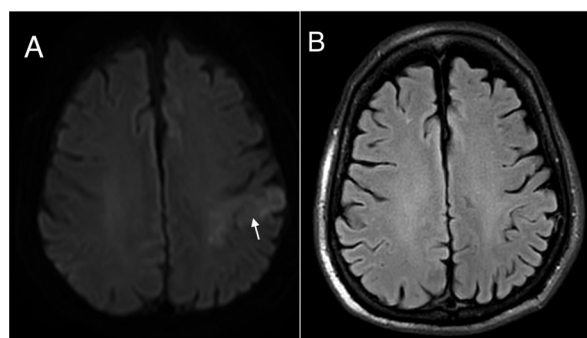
A – Axial DWI image (b=1000) showing a left parietal region acute infarct (white arrow). B – The corresponding axial FLAIR image shows no increased signal at the same region (FLAIR-negative).
